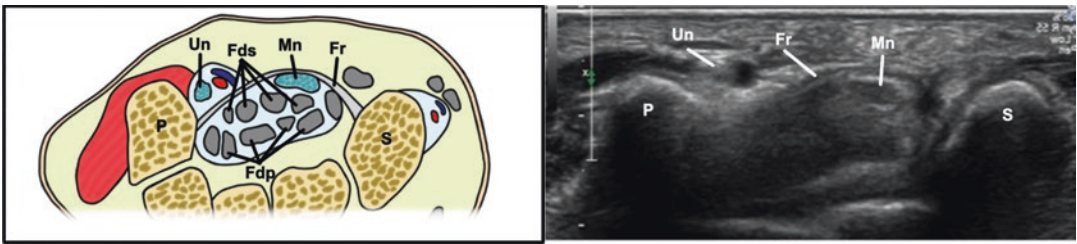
Axial ultrasound image—normal anatomy at the pisiform; *S* scaphoid, *C* capitate, *H* hamate, *T* triquetrum, *P* pisiform, *Mn* median nerve, *Un* ulnar nerve, *Fdp* flexor digitorum profundus, *Fds* flexor digitorum superficialis, *Fr* flexor retinaculum
